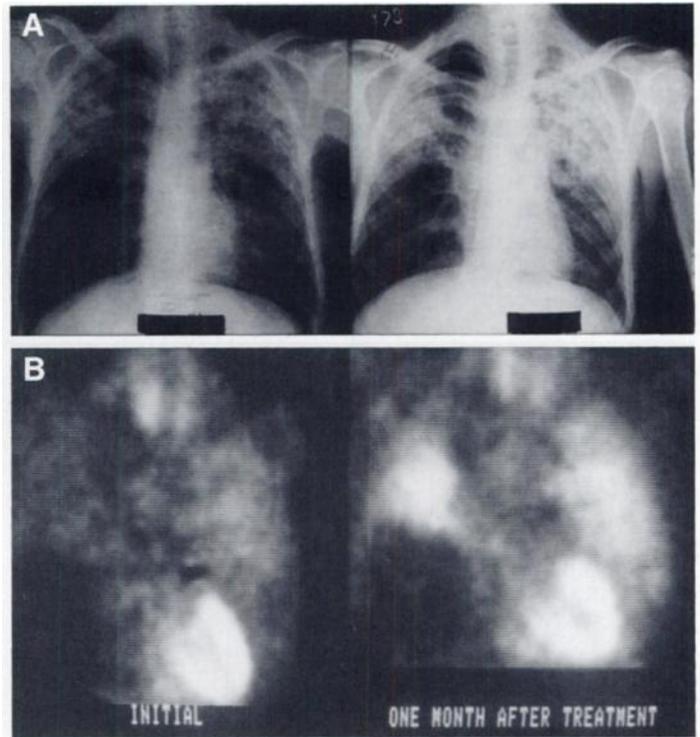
Patient 11, a 37-yr-old man with bilateral PTB. Cavitary disease together with fibronodular infiltrations are present in the right upper and also in the left upper-mid lung zones on the chest roentgenograms; they are more prominent on the post-therapy radiograph, indicating disease progression. The corresponding MIBI scans demonstrate similar changes more apparently.
